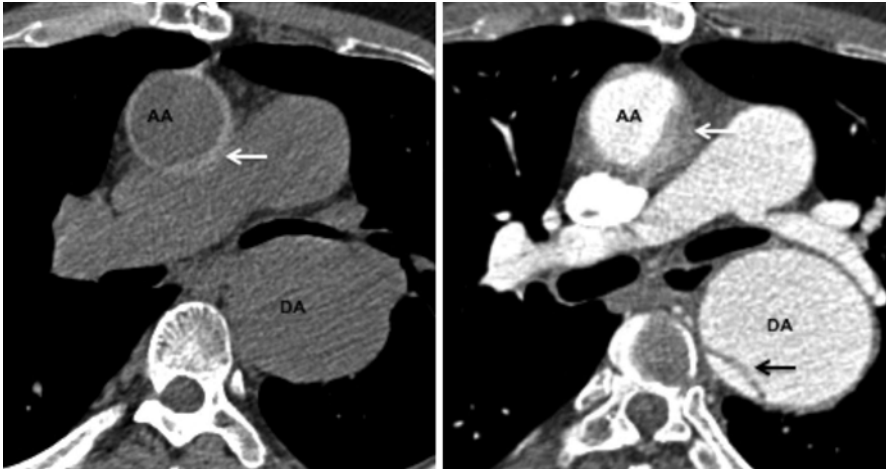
A 70-year old hypertensive male with acute chest pain. *Left panel* is unenhanced axial CT image demonstrating crescentic high attenuation (*arrow*) in the ascending aorta (AA). *Right panel* is the corresponding post IV contrast medium image with non-enhancing intramural hematoma (*arrow*). The descending aorta (DA) is aneurysmal and has a focal dissection flap (*black arrow*)
